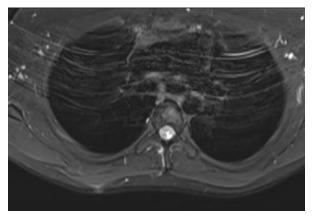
Magnetic resonance T2-weighted image at 8 months postoperatively showed no findings suggesting a retear of the rhomboid major.
